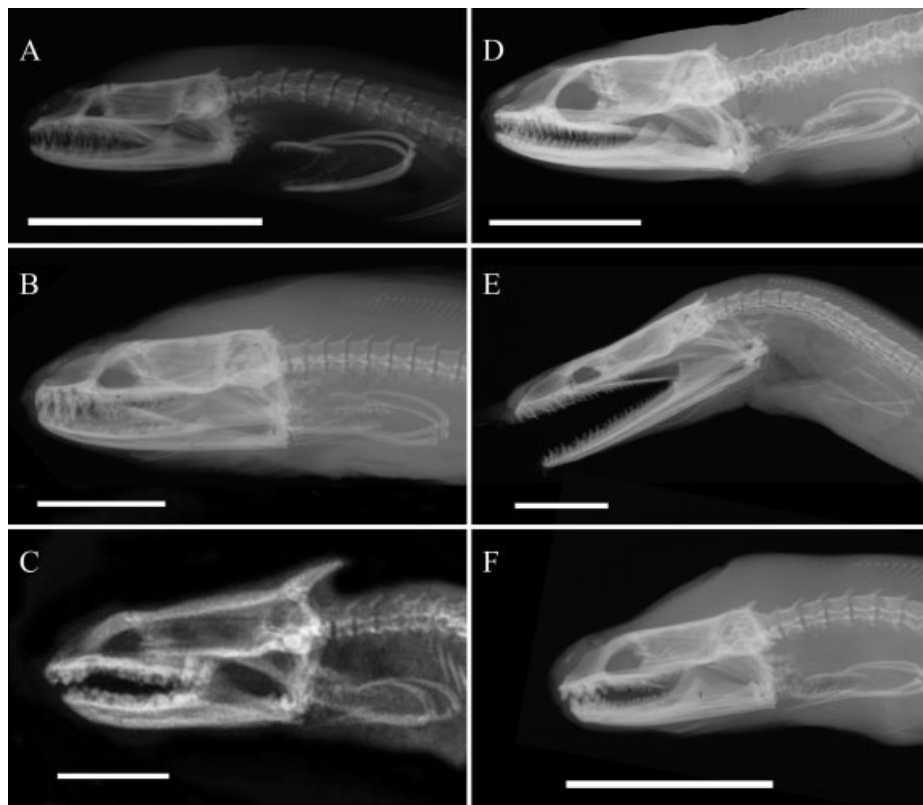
Radiographs depicting the well-developed pharyngeal jaw apparatus of moray eels. A: *Anarchias seychellensis* (Uropterygiinae). B: *Gymnothorax javanicus* (Muraeninae). C: *Gymnomuraena zebra* (Muraeninae). D: *Uropterygius macrocephalus* (Uropterygiinae). E: *Rhinomuraena quaesita* (Muraeninae). F: *Echidna nebulosa* (Muraeninae). Scale bar = 1 cm.
